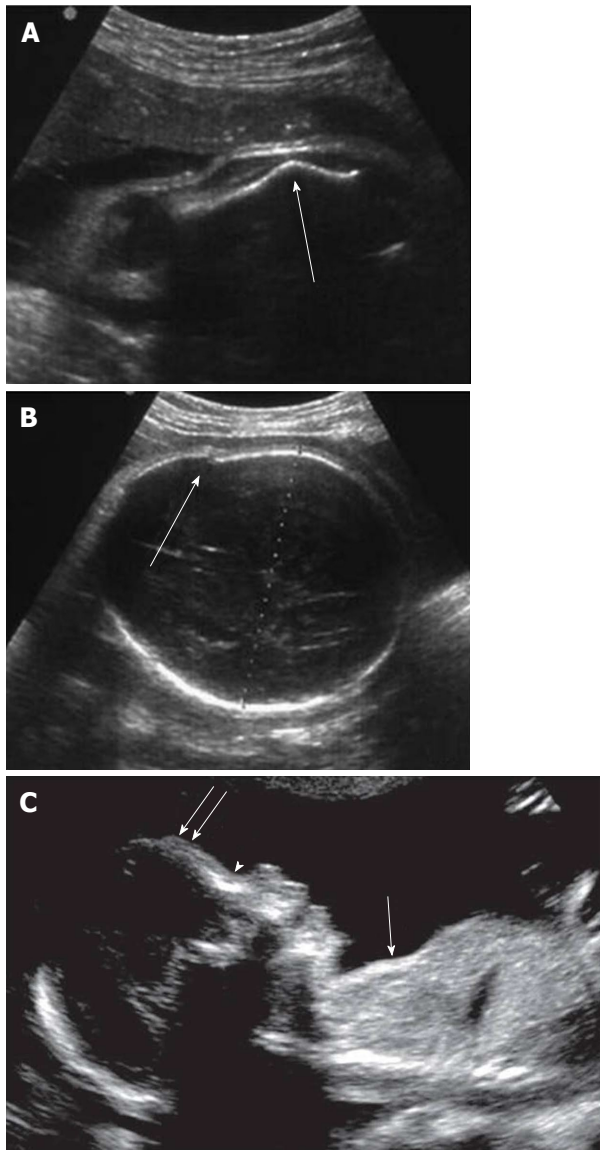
Marker of skeletal dysplasia by two-dimensional ultrasound. A: Abnormal angulated femur; B: Osteogenesis imperfecta: cranial vault distortion upon probe pressure. (Adapted from Cassart^[98]); C: Features of thanatophoric dysplasia: depressed nasal bridge (arrowhead), prominent forehead (double arrows), and undersized thorax (single arrow) compared with the abdomen. Adapted from Dighe *et al.*^[99].
